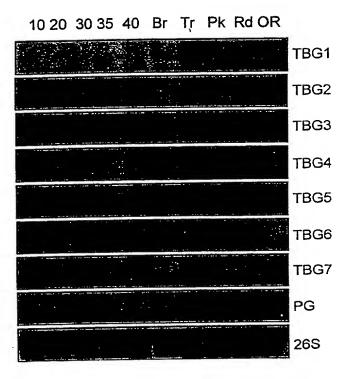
Autoradiograph of northern blot analysis of TBG expression in fruit tissues. Twenty μg of total RNA extracted from peel and outer pericarp tissue was loaded in each lane. Fruit were harvested at 10, 20, 30, 35, and 40 days post-pollenation and at the breaker (Br), turning (Tr), pink (Pk), red (Rd) and over ripe (OR) stages. RNAs were separated in an agarose gel and transferred to nylon membrane. Blots were hybridized using the probes indicated to the right, washed to a final stringency of 0.1X SSC at 65°C and were used to expose x-ray film. A 26S ribosomal gene clone from soybean was used as a loading control for each blot and one example is shown. A cDNA clone for tomato polygalacturonase (PG) was also used as a probe to show a well characterized, fruit-ripening-specific control.
